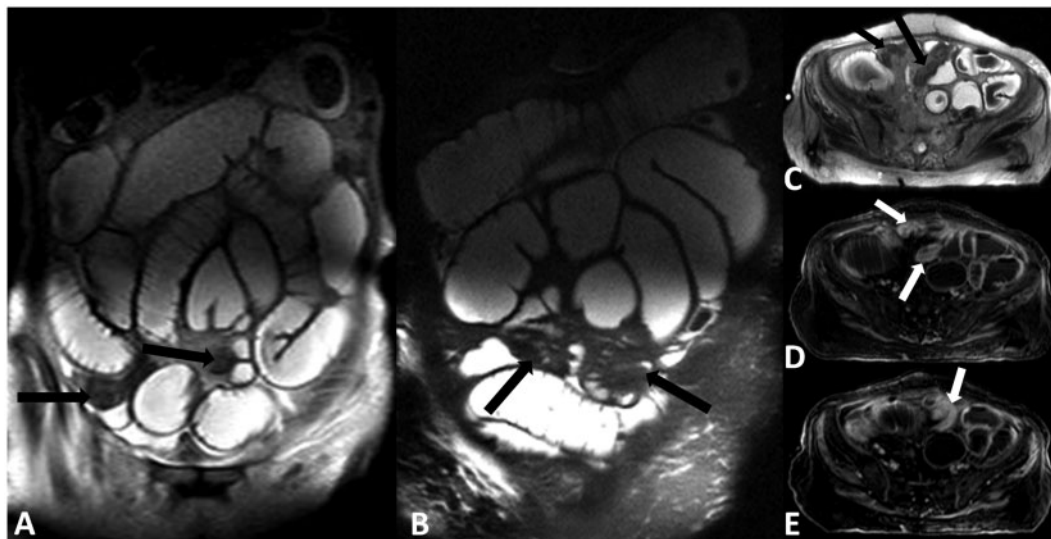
Case 3. Coronal (A,B) and axial (C) fat-saturated HASTE images of the patient demonstrate proximal small bowel dilatation and long segment thick-walled small bowel stricture (distal ileum) with luminal narrowing (black arrows). Axial post-contrast fat-saturated T1W MR images show thick-walled and narrowed small bowels with enhancing mucosa (white arrows in D and E). Imaging findings are consistent with chronic radiation enteritis.
